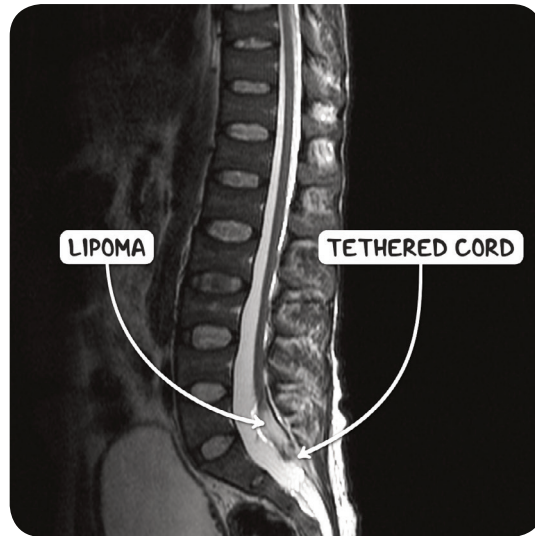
An MRI scan of the spine in the sagittal plane demonstrating a tethered spinal cord associated with a lipoma of the filum terminale.
